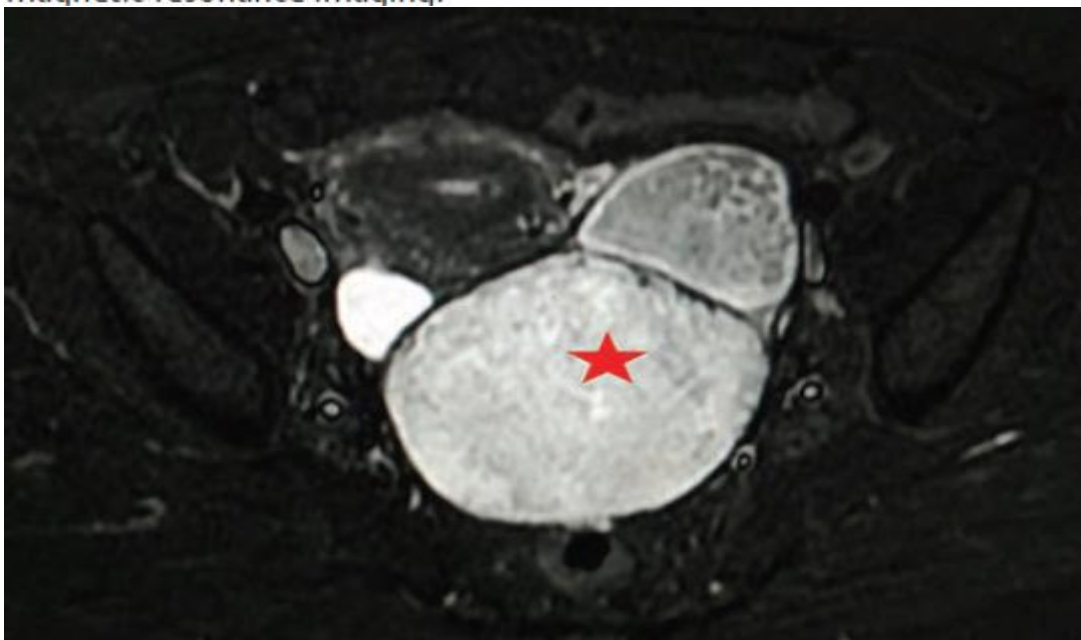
Axial STIR MRI demonstrating a thin walled heterogeneously hyperintense lesion (star) in the left adnexa: findings are of concern for atypical teratoma versus malignant etiology. MRI, magnetic resonance imaging.
